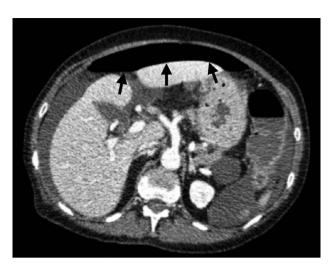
CT angiogram abdominal aorta and portal venous phase CT: There is a large volume of free gas noted in the ante-dependent portion of the peritoneal cavity (arrows). This is consistent with a bowel perforation; however, a definite site of perforation was not seen on CT.
